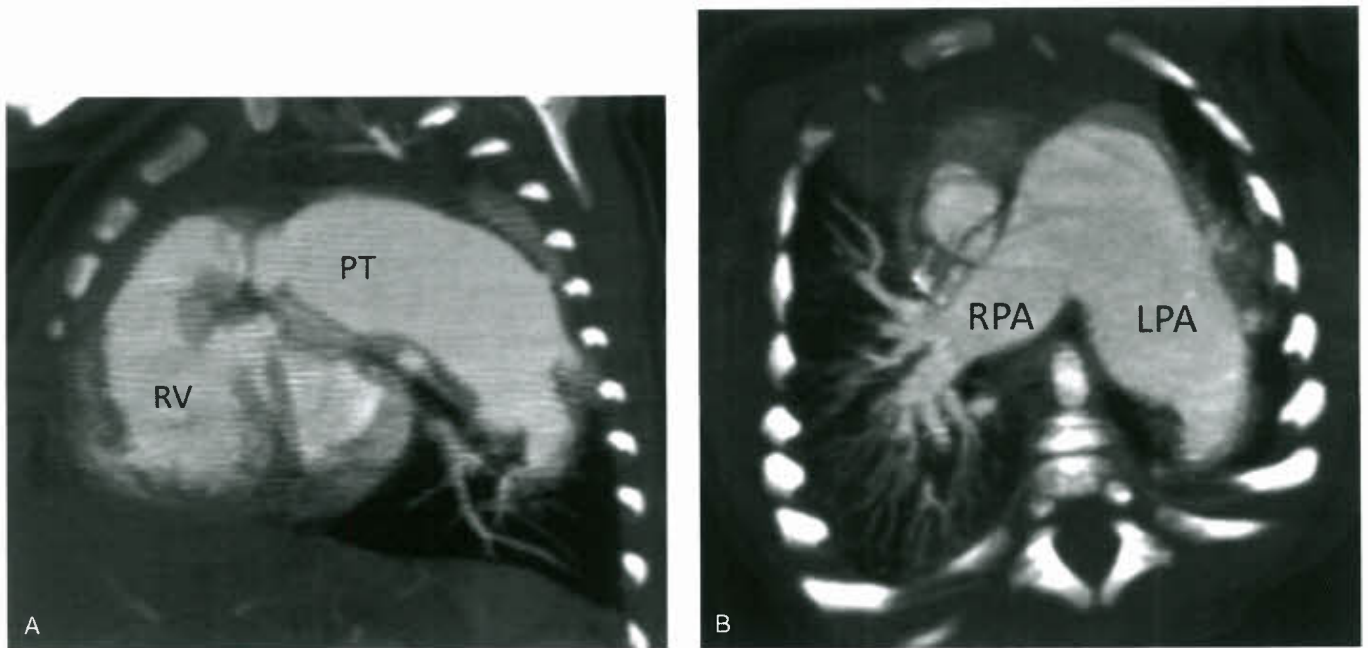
MRI of infant with TOF with absent pulmonary valve. Note the massive dilatation of main and branch pulmonary arteries. RV, Right ventricle; PT, Pulmonary trunk; LPA, Left pulmonary artery; RPA, Right pulmonary artery. (Images courtesy of Dr. Shi-Joon Yoo at The Hospital for Sick Children, Toronto.)
